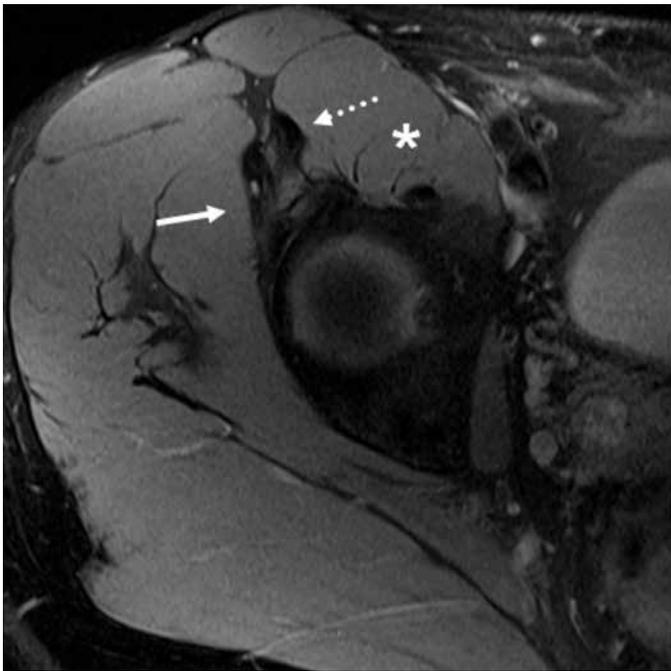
Axial proton density (fat suppression) MRI: Pelvic digit (arrow) situated anteroinferiorly near the right acetabulum and in close proximity to the tendon of the m. rectus femoris (dotted arrow) and lateral fascia of the m. iliopsoas (asterix).
